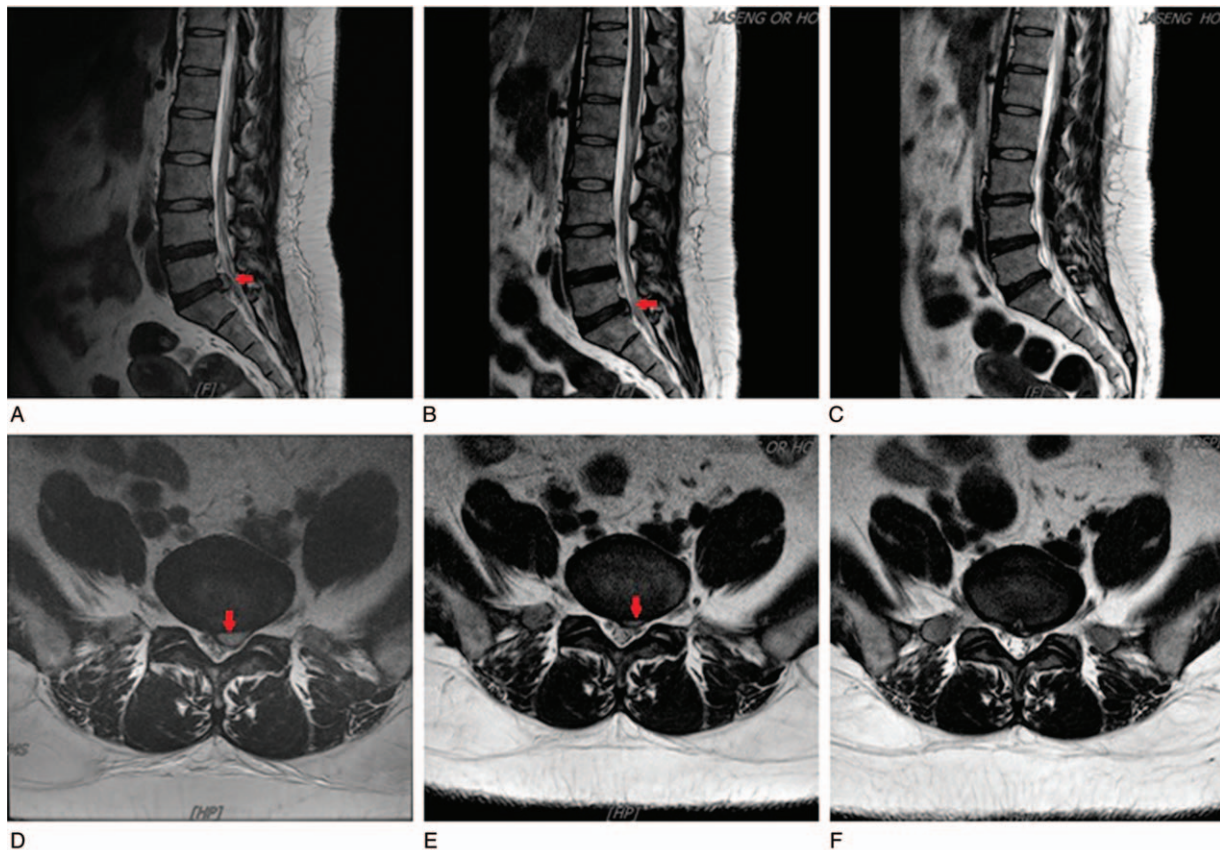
Process of discal cyst resorption shown on T2-weighted MRI [A, D]. Confirmed that presence of discal cyst at L5-S1 is compressing the left S1 nerve root at initial Examination [B, E]. Confirmed remarkable spontaneous regression at first f/u on day 36 [C, F]. Confirmed resorption of discal cyst at second f/u on day 99. MRI = magnetic resonance imaging.
